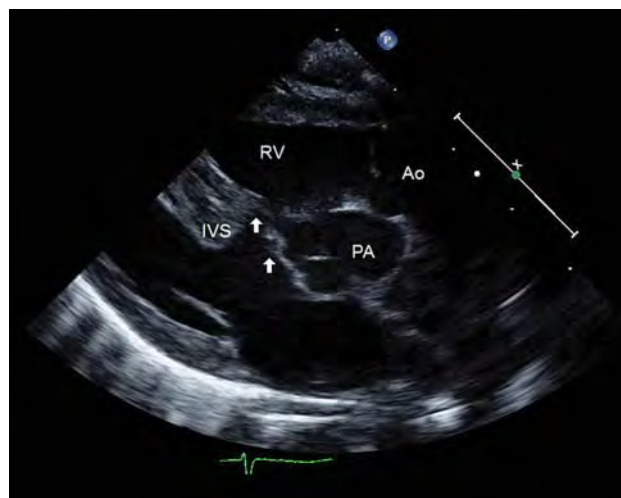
Parasternal long-axis view demonstrating straddling of the mitral valve (arrows) through the VSD, obstructing the subpulmonary area. Ao, aorta; IVS, interventricular septum; PA, pulmonary artery; RV, right ventricle.
